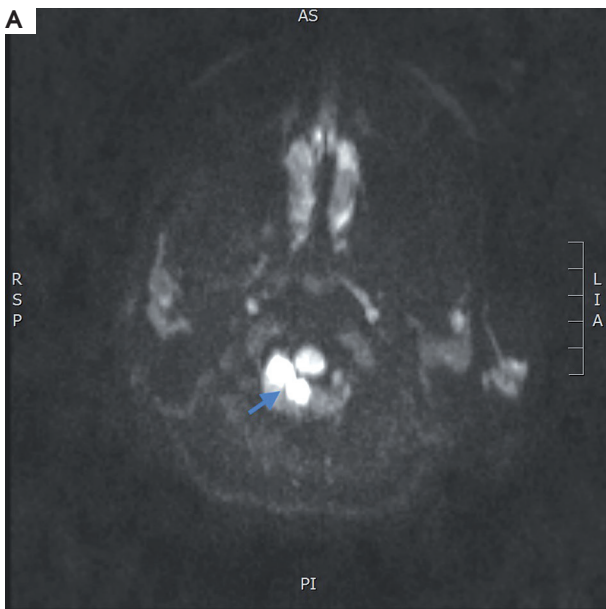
Magnetic resonance imaging of the head in the T2-dependent sequence: ischemic focus in the cerebellum in the right hemisphere, medulla (arrow)
